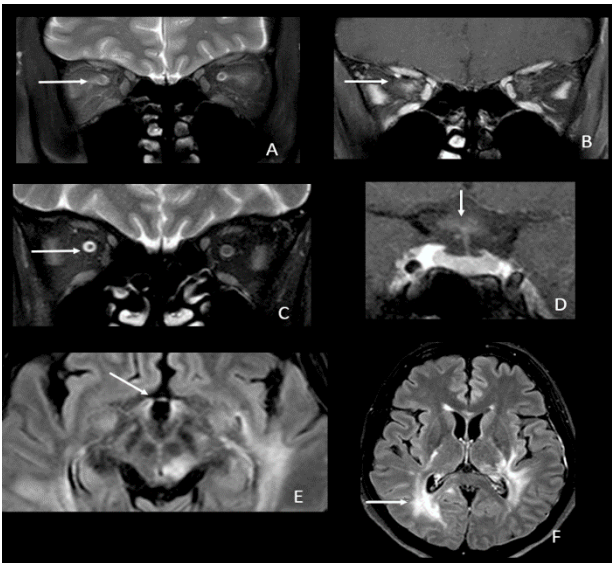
Optic MRI. Unilateral right optic neuritis along intraorbital part on coronal (A) T2WI/FS and (B) on coronal T1WI/Gd/FS; (C) Right optic nerve atrophy on coronal T2WI/FS; (D) Optic neuritis at optic chiasm on coronal T1WI/Gd/FS; (E) Involvement at both optic tract; (F) Involvement of optic radiation
